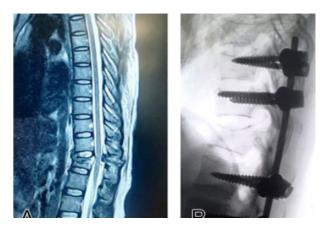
A: MRI dorsolumbar spine revealed L1 fracture. B: Post-operative X-rays revealed long segment fixation, kyphosis correction, and vertebral body height(VBH) restoration.
